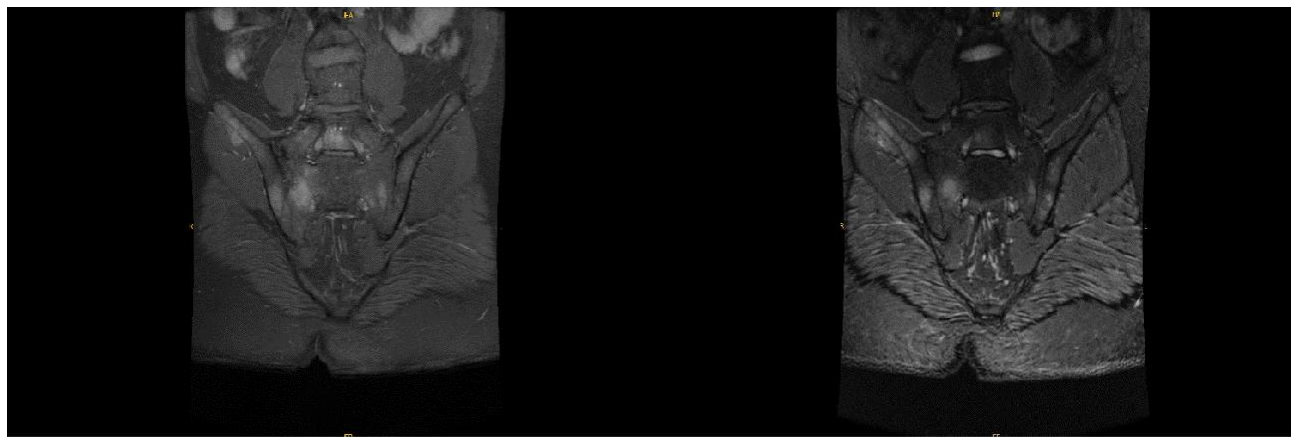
Pathological signal increase in bilateral sacral wing and iliac bone medulla, narrowing in both sacroiliac joint spaces, and findings suggestive of bilateral sacroiliitis in the sacroiliac MRI COR-STIR of the first case.
